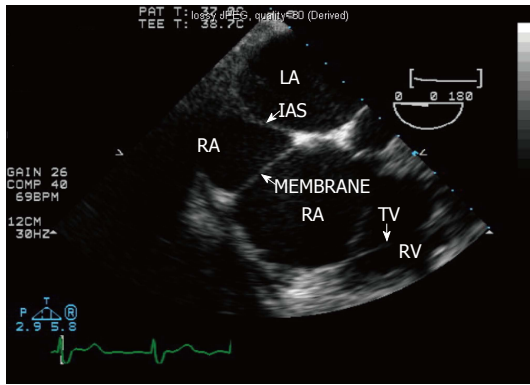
Four-chamber transesophageal echocardiogram view showing the division of the left atrium into two chambers by a transverse membrane. IAS: Interatrial septum; LA: Left atrium; RA: Right atrium; RV: Right ventricle; TV: Tricuspid valve.
